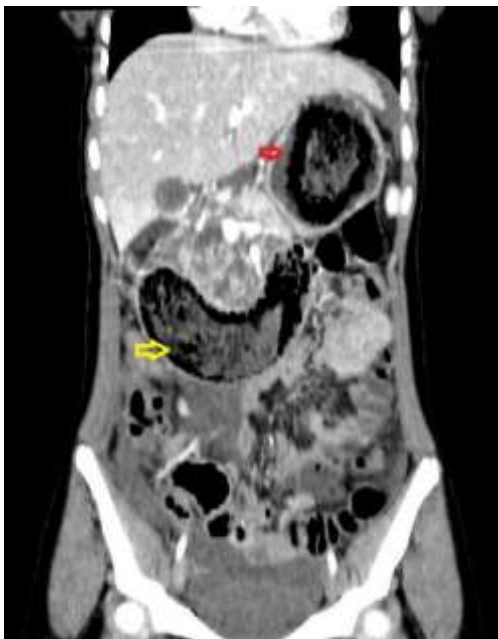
Coronal section of abdominal CT scan showing the Trichobezoar in the stomach and duodenum. Red arrow points to the gastric trichobezoar, and the yellow arrow points to the duodenal trichobezoar.
